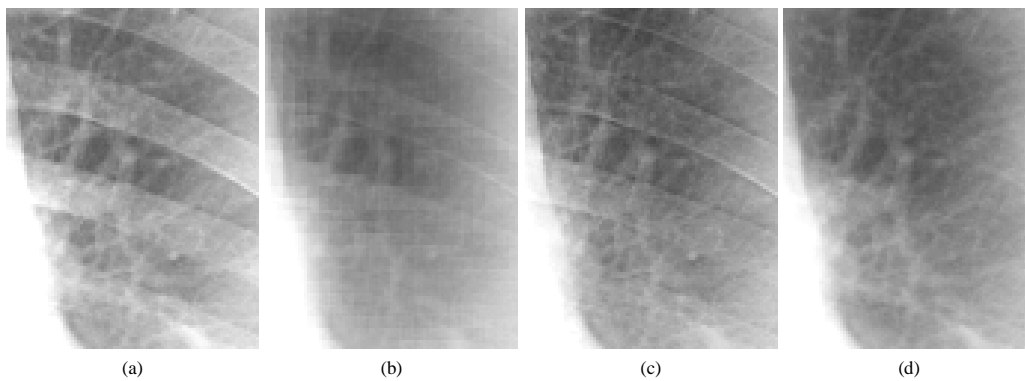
Enlarged images of ROIs in (a) original chest radiograph, (b) “soft-tissue-image-like” image obtained by use of the MTANN, (c) bone-subtracted image obtained by use of our scheme, and (d) “ideal” soft-tissue image obtained by use of the dual-energy subtraction technique.
